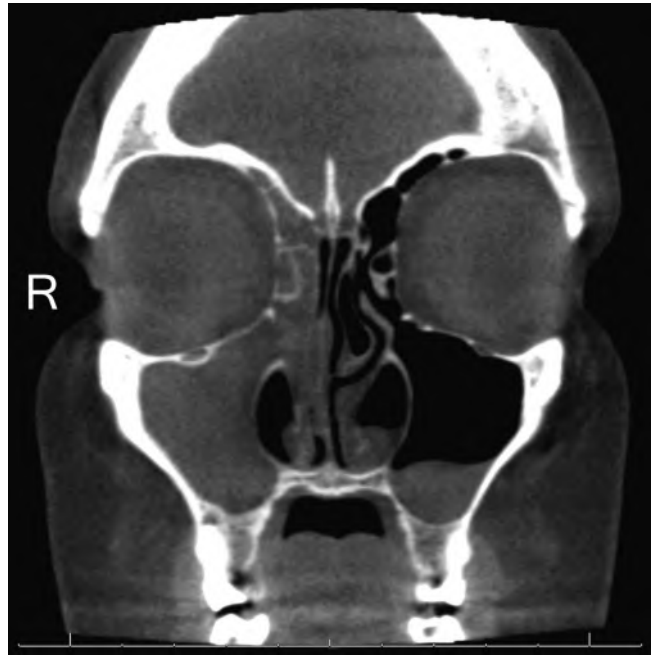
Rhinosinusitis. Coronal CT image shows fully obstructed right (R) maxillary, ethmoid, and frontal sinuses, as well as mucosal thickening on the floor of the left maxillary sinus.
